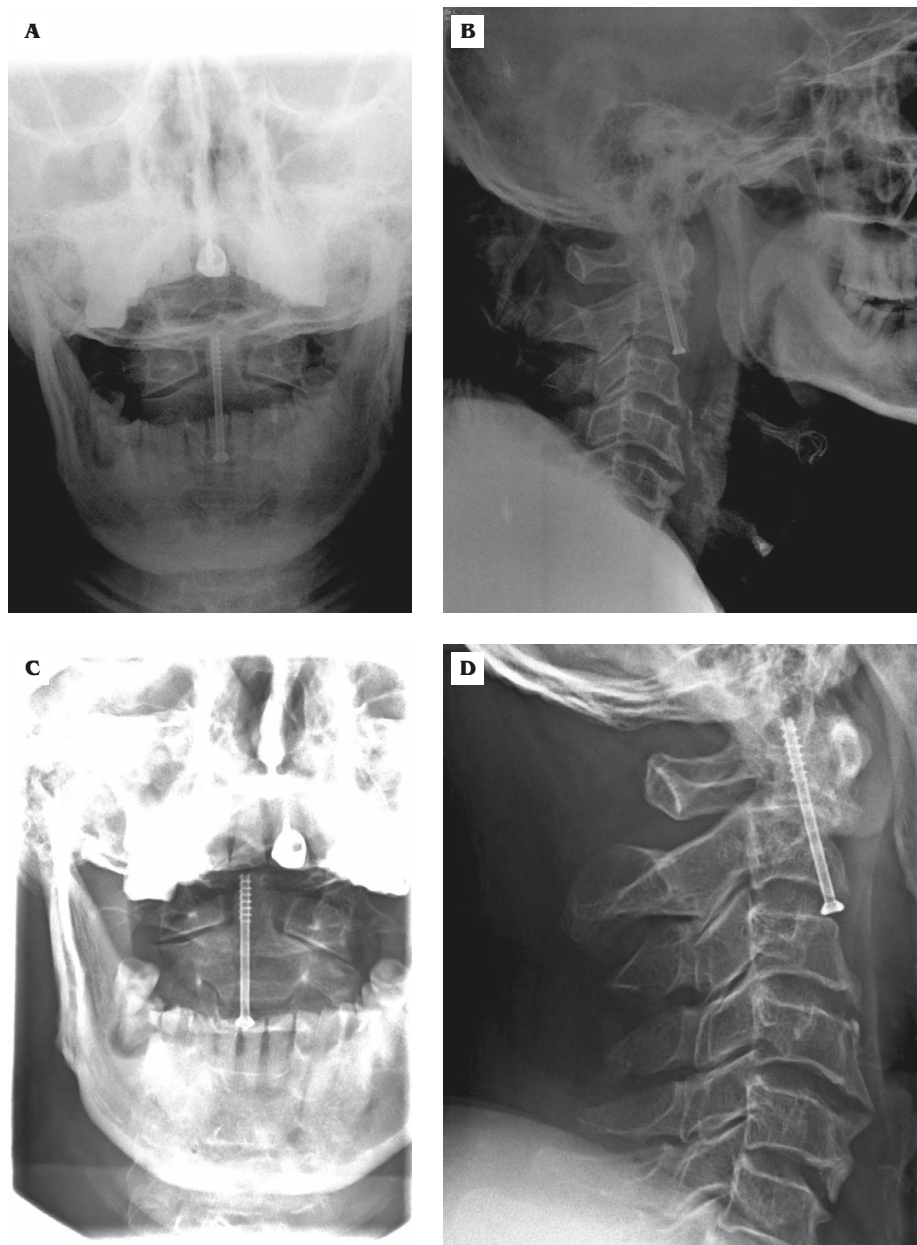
(A, B) Radiograph immediately after the operation. (C, D) Radiograph 90 days after the operation.
